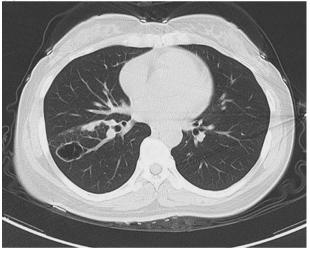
A 34-year-old woman, anti-TB therapy for 6 months. (a) Computed tomography (CT) revealed a thin-walled cystic lesion in right lower lobe. (b) CT was taken 6 months later. An enlarged thin-walled cystic lesion associated with interlobar pleural metastasis.
